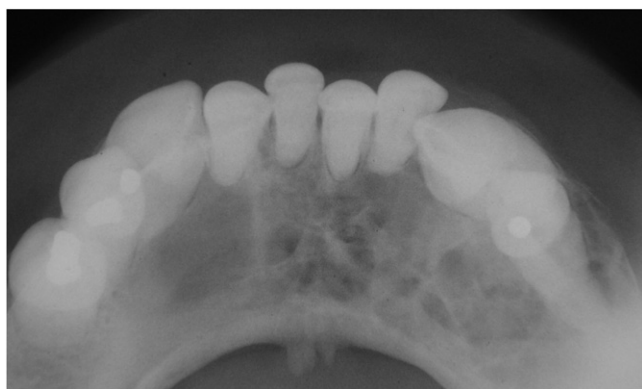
Radiograph showing a multilocular cystic lesion extending from the root of the right premolar to the left premolar in case 1.
